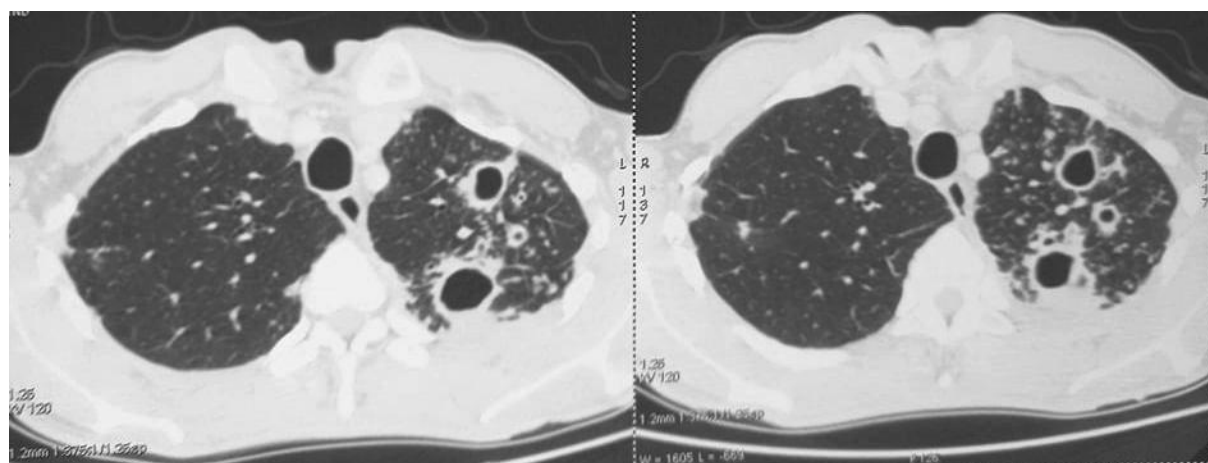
Axial chest computed tomography scan (lung window) shows left lung micronodules, multiple cavitations and bronchiectasis.
